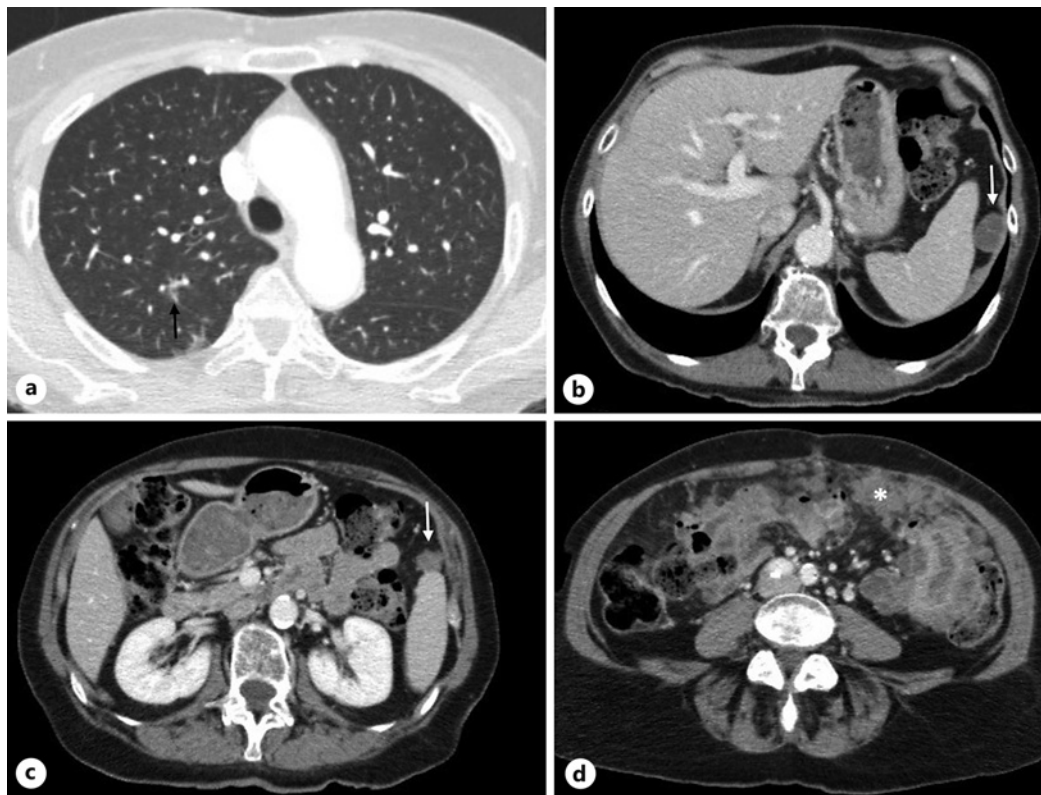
First CT control 2 months after the start of immunotherapy. Volumetric CT MPR images in the axial (a–d) planes after intravenous contrast media administration. a Reduction in size of lung metastasis appearing as a ground-glass band (black arrow) in the posterior segment of the upper lobe of the right lung. b–d Reduction in size and density of peritoneal nodules (white arrows) and omental masses with initial restoration of fat density between confluent nodules (asterisk).
